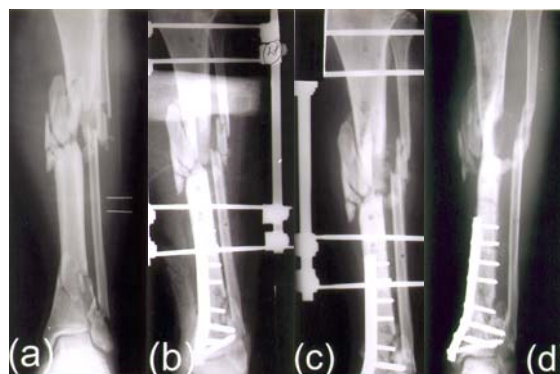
A leg, tibial radiographs of a 41-year-old man who sustained a Grade III-A open segmental fracture (a). Eight weeks after the injury (b), the early prophylactic bone grafting at the comminuted segmental fracture was performed by percutaneous technique (c). Union was achieved at 18 weeks after the procedure (d).
